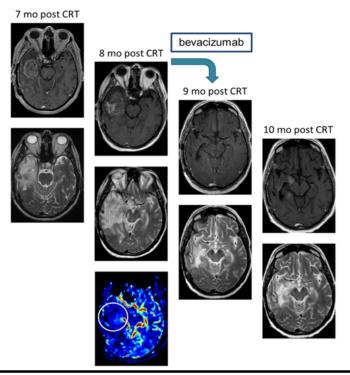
Pseudoprogression after immunotherapy. This Patient received Celldex vaccine (an investigational immunotherapy that targets the tumor specific oncogene EGFRv3) at 5 and 6 months after CRT and 4 monthly cycles of adjunct temozolomide for glioblastoma. A dramatic increased mass effect was noted 7-8 months post CRT and 1-2 months post Celldex vaccine. T1+Gd MRI Column 1: 7 months after CRT showing residual enhancing lesion in the right temporal lobe. Column 2: 8 months after CRT showing increase size of the lesion and exuberant vasogenic edema and mass effect on the lateral ventricle and midline shift. DSC ferumoxytol perfusion MRI 8 months after CRT showing decreased rCBV in the enhancing area in the right temporal lobe, suggesting pseudoprogression. At this point the patient might be falsely classified as disease progression by updated RANO criteria. Patient was continued on temozolomide based on our blood volume measurements. He was given one dose of bevacizumab as an anti-edema measure in addition to high dose steroids. He had to be taken off the clinical trial because the trial excluded patients on bevacizumab. Column 3: 9 months after CRT and 4 weeks after one dose of bevacizumab MRI showed significant improvement in the enhancement, vasogenic edema and mass effect. Column 4: 10 months after CRT and 8 weeks after bevacizumab showing minimal increase of enhancement and mass effect, still significantly better than before bevacizumab. This case clearly demonstrates the inadequacies of conventional MRI scans and RANO criteria and shows blood volume measurements is better imaging biomarker than enhancement.
